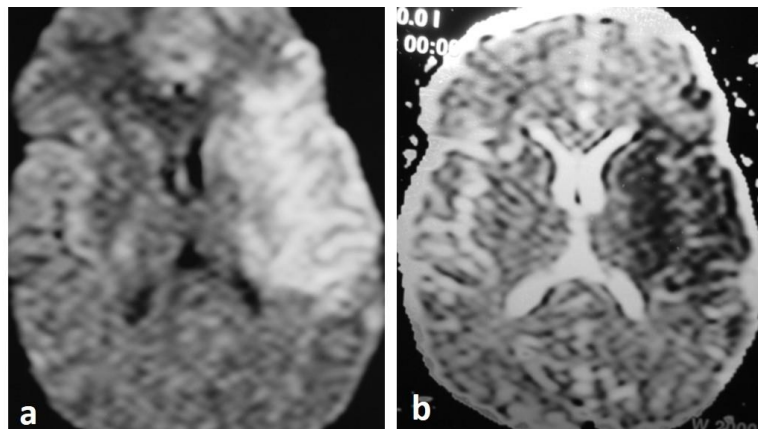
(a) DWI-b1000, a large zone of hyper intense signal (restricted diffusion) in the Lt. temporo-parietal region. (b) ADC Map shows hypo intense signal of the same lesion (same case as in figure 3).
